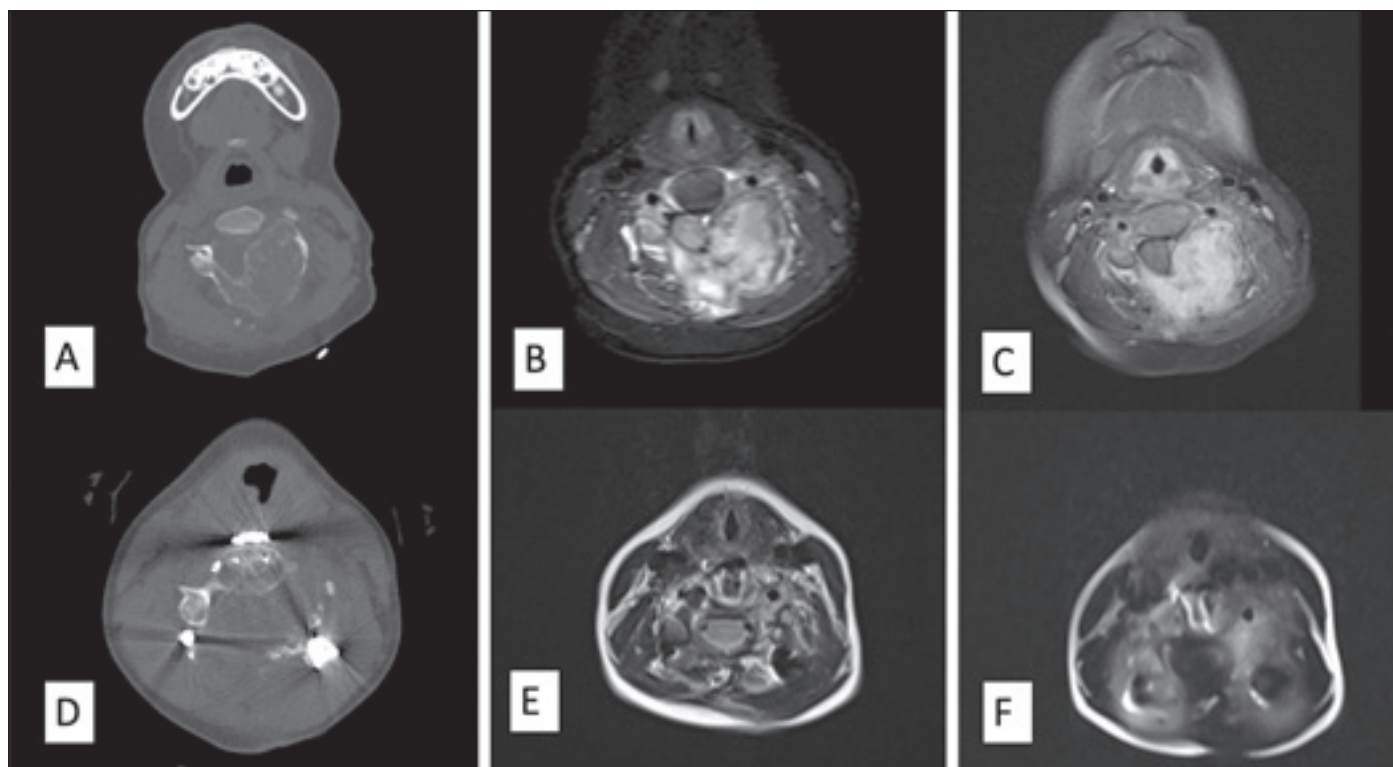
Images of the osteblastoma patient who underwent instrumentation (Patient 18): (A) preoperative axial CT image; (B) preoperative axial T2-weighted MRI image; (C) preoperative axial postcontrast T1-weighted MRI image; (D) postoperative axial CT image; (E) postoperative axial T2-weighted MRI image; (F) postoperative axial postcontrast T1-weighted MRI image.
